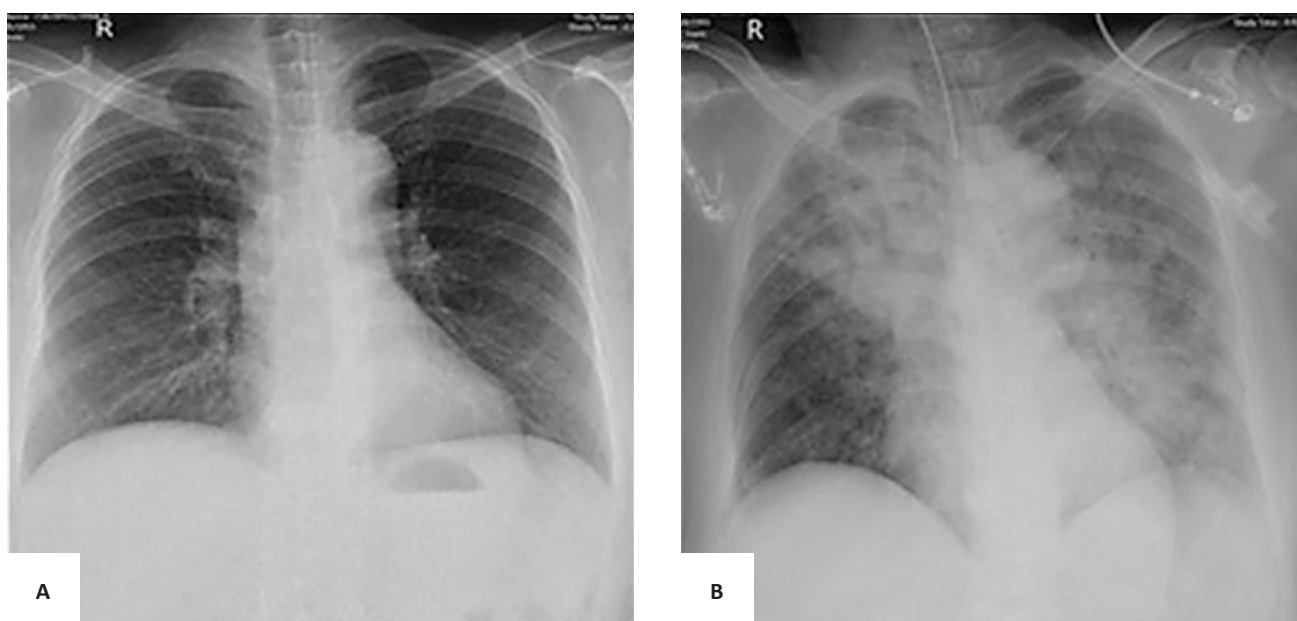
Chest X-Ray. (A) Pre-operative exam showing normal lung parenchyma, normal cardiac silhouette and elongated aorta. (B) Post-operative exam showing bilateral air-space filling opacities.
